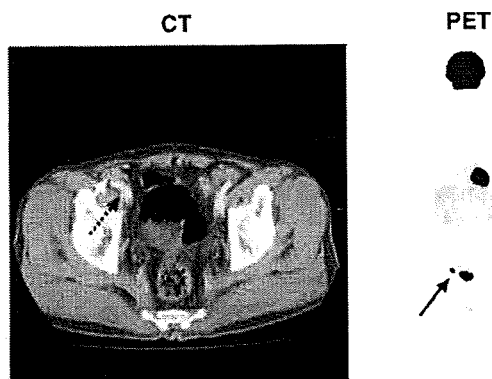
CT and PET findings. Delineated is a mass on the abdominal side of the right external iliac vessels. Solid line, tumor; dotted line, external iliac vessels.
